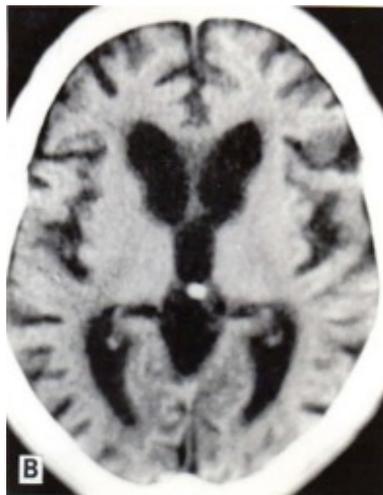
CT scan without contrast showing severe cerebral atrophy, dilatation of the III ventricle and severe atrophy in the head of caudate nuclei, in the same patient with familial HD [8].
